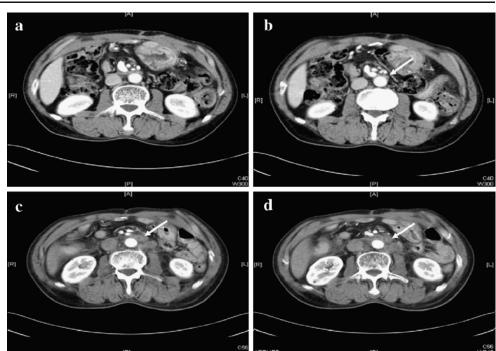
Imaging studies of a patient with aortocaval lymph node recurrence with increased serum CA 19-9 level. a, b Axial CT scans showing a huge aortocaval lymph node metastasis.
